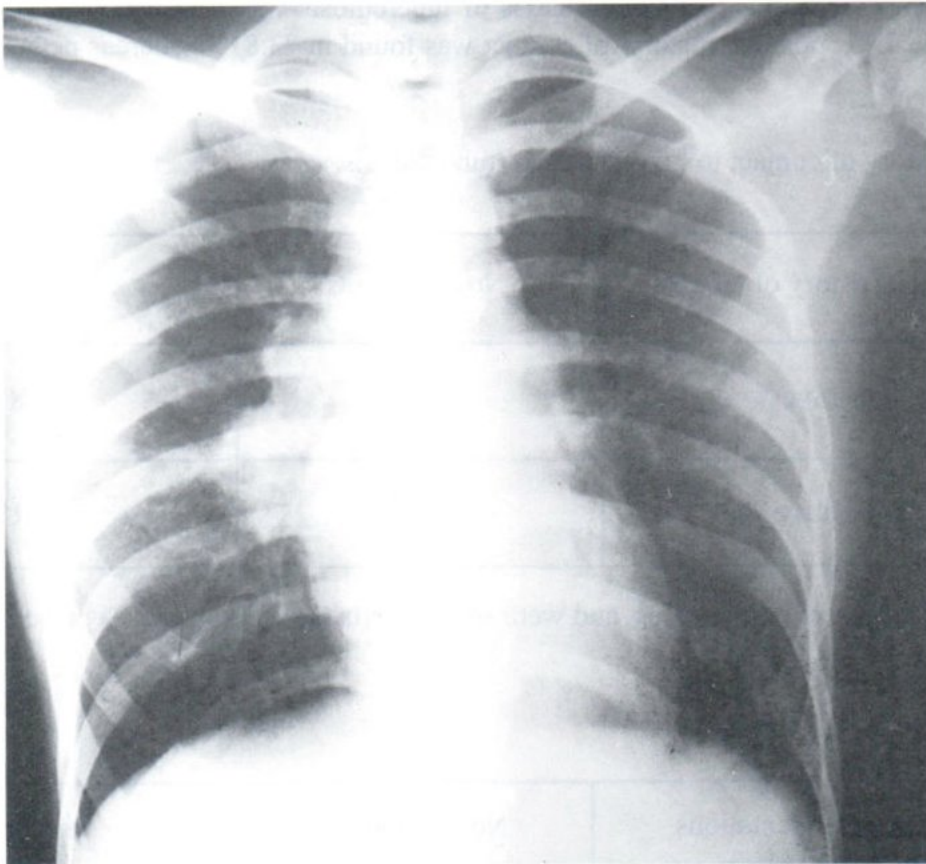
A 10 year old girl with clinical history suggestive of tuberculosis. PA chest radiograph shows right broncho-pulmonary, hilar and para-tracheal adenopathy.
